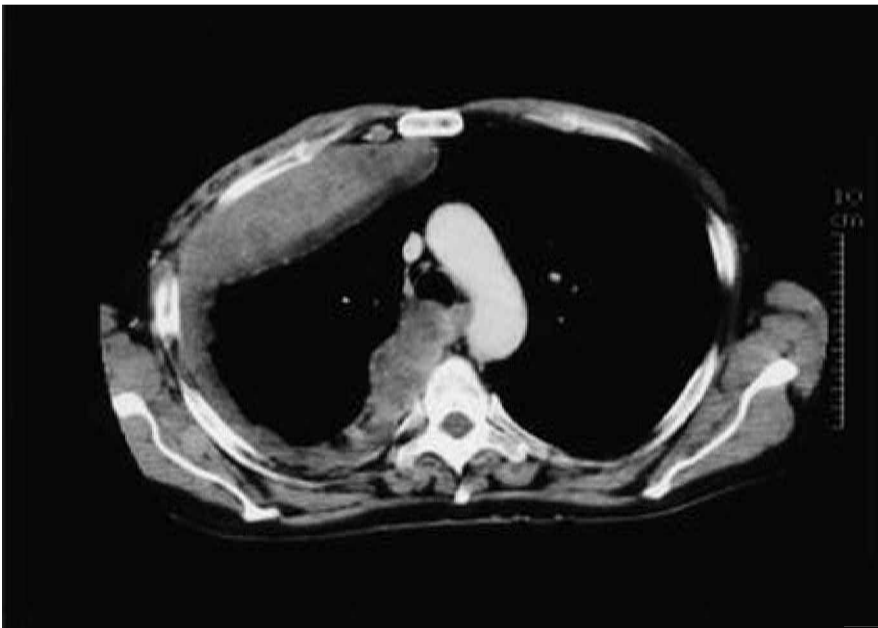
Computed tomography appearance of mesothelioma. A thickened rim of tumour arising from the pleura is beginning to encase the right lung. Characteristic findings are pleural thickening (92% of patients), thickening in the intralobar fissures (86%), effusions (74%) and pleural calcifications (20–50%).^{3,4}
